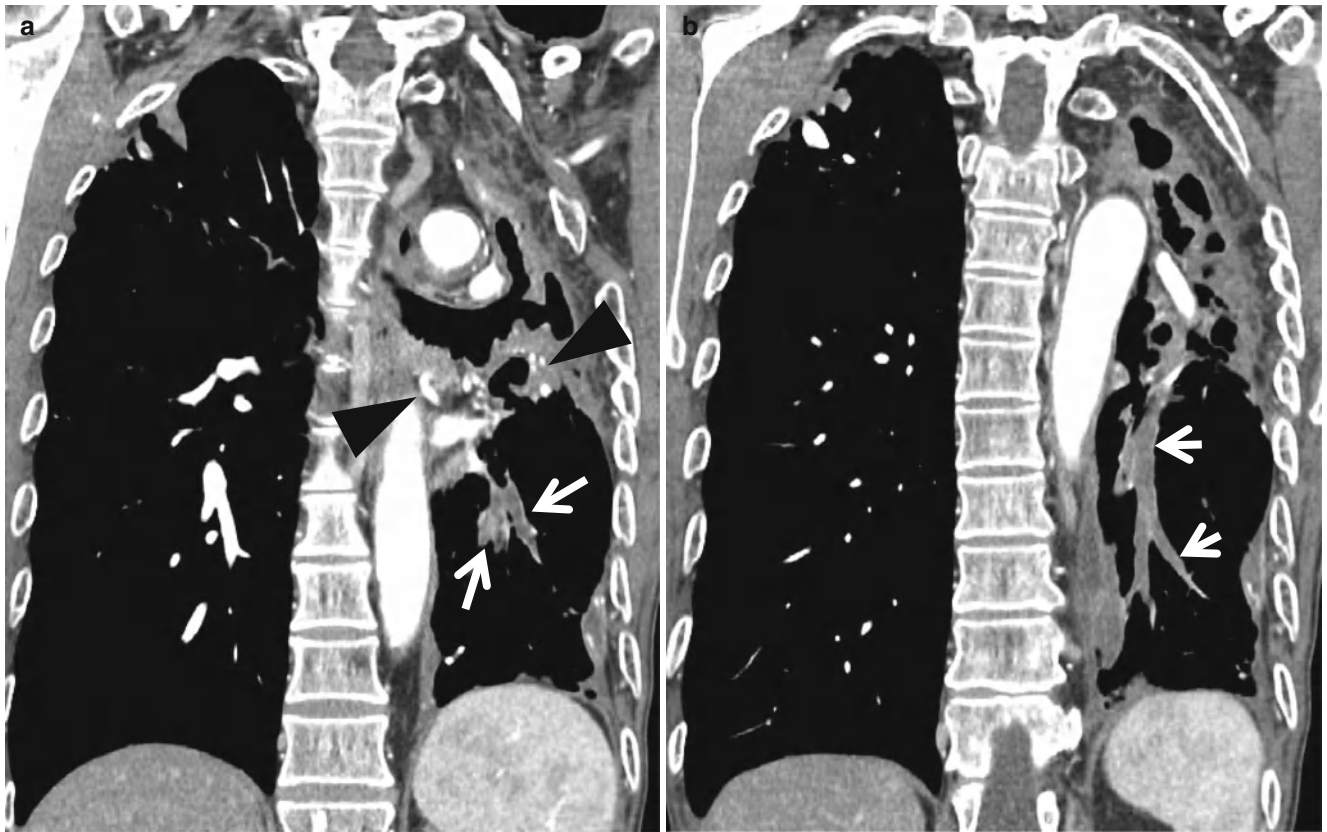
Gloved finger sign associated with tuberculous bronchial stricture involving the left lower lobar bronchus in a 67-year-old man who had a history of previous tuberculous infection. (a, b) Mediastinal window and coronal reformatted images (2.0-mm section thickness) of enhanced CT scans obtained at levels of the descending thoracic aorta
